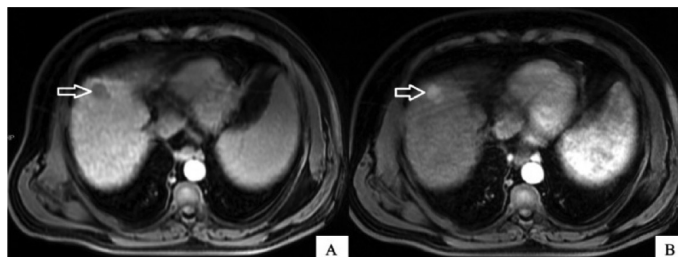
HCC lesion on MRI, hypointense mass in the hepatobiliary phase (A), and contrast-enhancing mass in the arterial phase (B).
